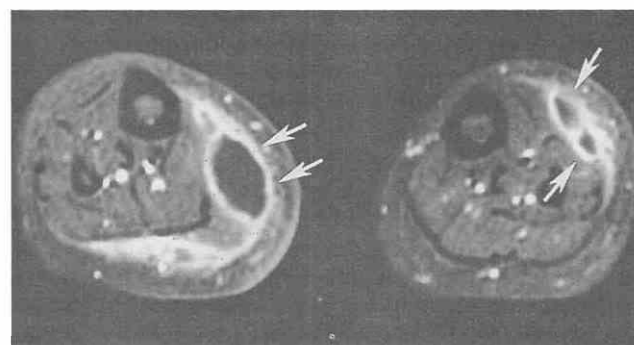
Pyomyositis in an 11-year-old girl. Axial postgadolinium T1-weighted image (TR = 417 msec, TE = 12 msec) with fat saturation shows intramuscular abscesses (arrows) within both legs. Multiple additional abscesses were present within both legs. No source was identified. A drain was placed in the right calf abscess under sonographic guidance.
